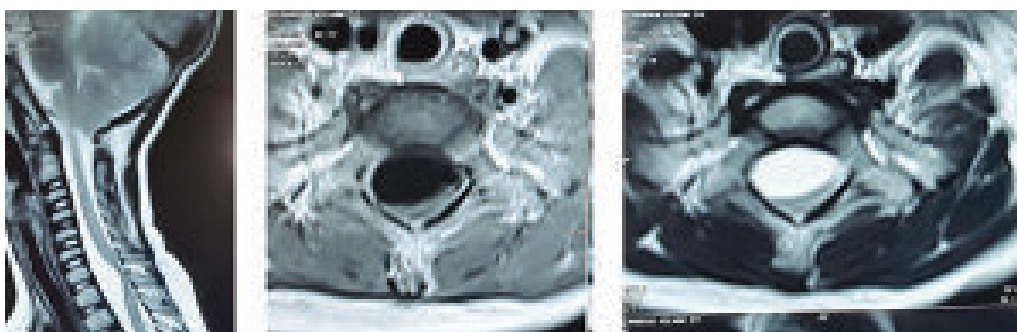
Pre-op MRI of cervical spine with contrast.
